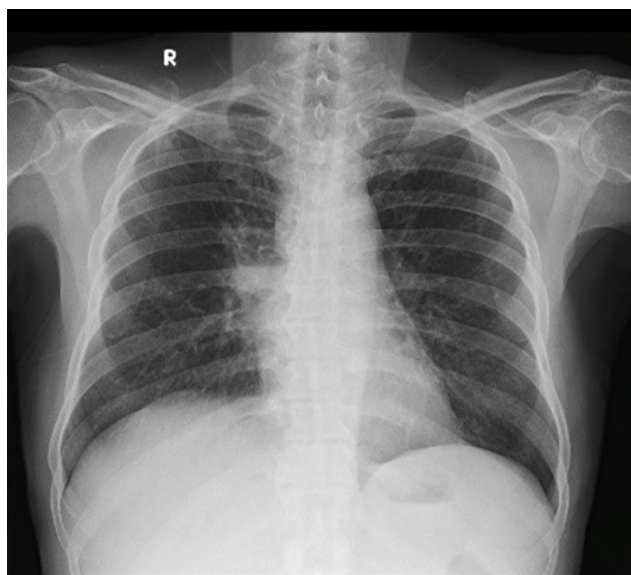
Frontal Chest Radiograph reveals a cystic lesion with air fluid level in the right midzone with the medial border abutting the mediastinal contour
